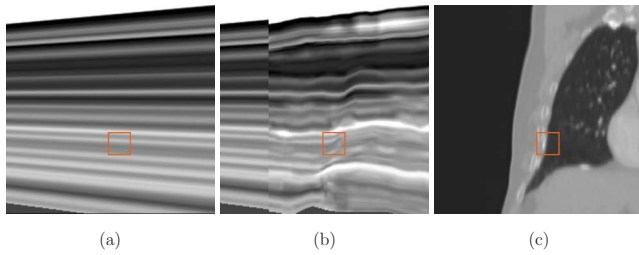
Coronal slice of (a) one straight backprojection and (b) one warped backprojection. (c) Corresponding slice of the planning CT image. The drawn square corresponds to the region displayed in Fig. 3. The vertical discontinuity in (b) corresponds to the limit of the 4D DVF which is only estimated in a bounding box encompassing the patient body.
